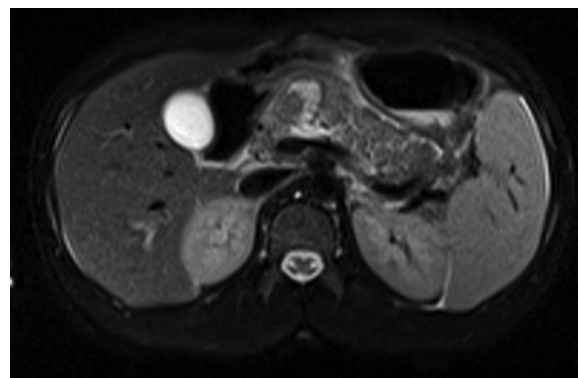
MRI of the abdomen (prior to MR cholangiopancreatography reconstruction) showing the proximally transected pancreas (grade IV pancreatic injury).
